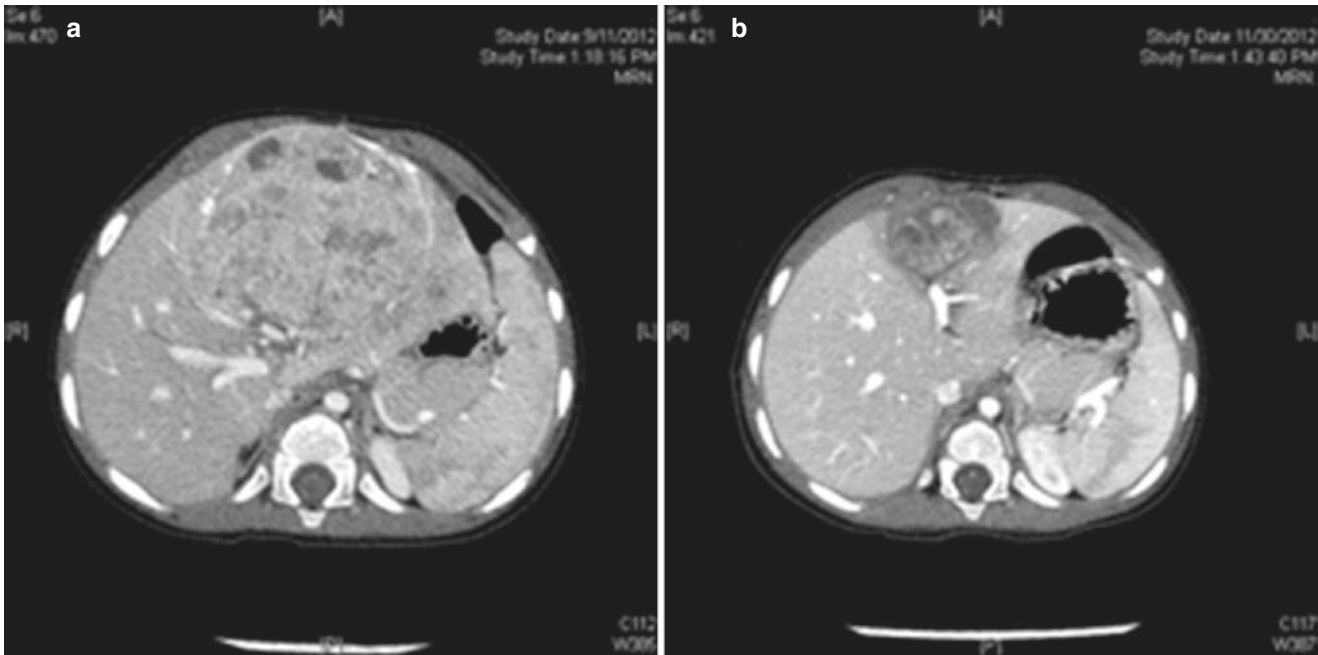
CT images of hepatoblastoma in a 1-year-old child. (a) CT at presentation showed a PRETEXT 2 disease with tumor involving the two left sectors. (b) CT following four cycles of chemotherapy prior to
